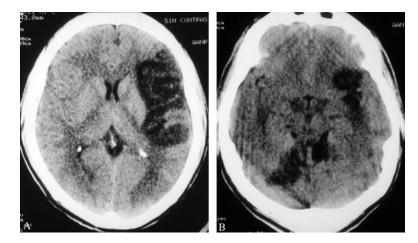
CT of a patient bitten by a Bothrops spp., taken 5 days after admission, showing infarcts in different cerebral artery territories related to Bothrops spp. envenoming.
